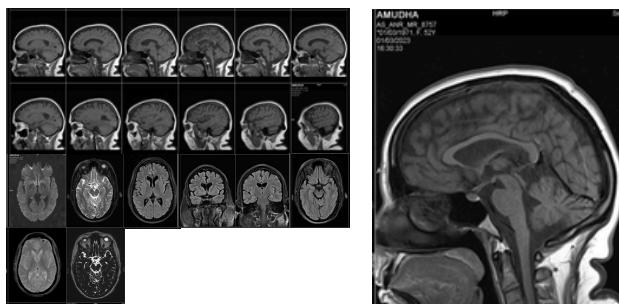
Fig 36, Fig 37 & Fig 38. MRI scans of Mrs. Amudha Kishore taken on March 1, 2023 (The date of her diagnosis)
